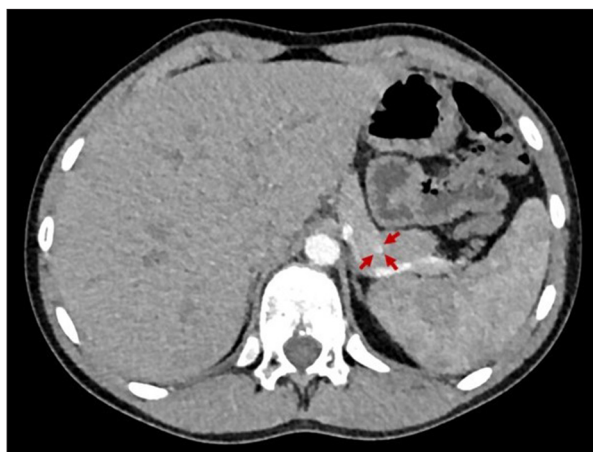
Dual-phase abdominal CT. Enhancing lesion measuring 10 mm in diameter in the junction of the body and tail of the pancreas.
